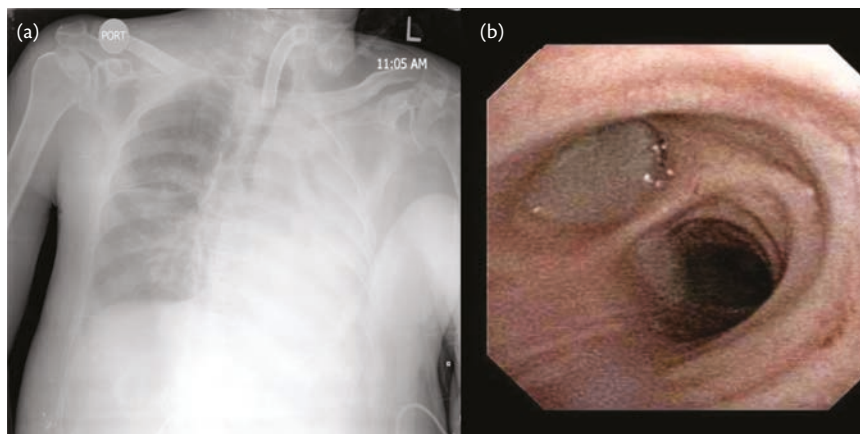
Toilet bronchoscopy indication. (a) Chest radiograph of a tracheostomized critically-ill patient who was admitted for acute exacerbation of chronic obstructive pulmonary disease. The radiograph depicts extensive left lung atelectasis with no evidence of air-bronchograms. (b) Following unsuccessful chest physiotherapy, toilet bronchoscopy showed full obstruction of the left main bronchus by copious airways secretions.
